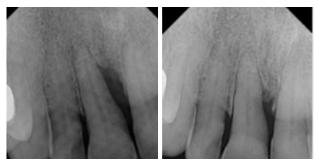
Bone regeneration observed on radiographic images of patient #5 before (left image) and 12 months following TwinLight® treatment (right image). Source: Dalessandro Implants and Periodontics.
